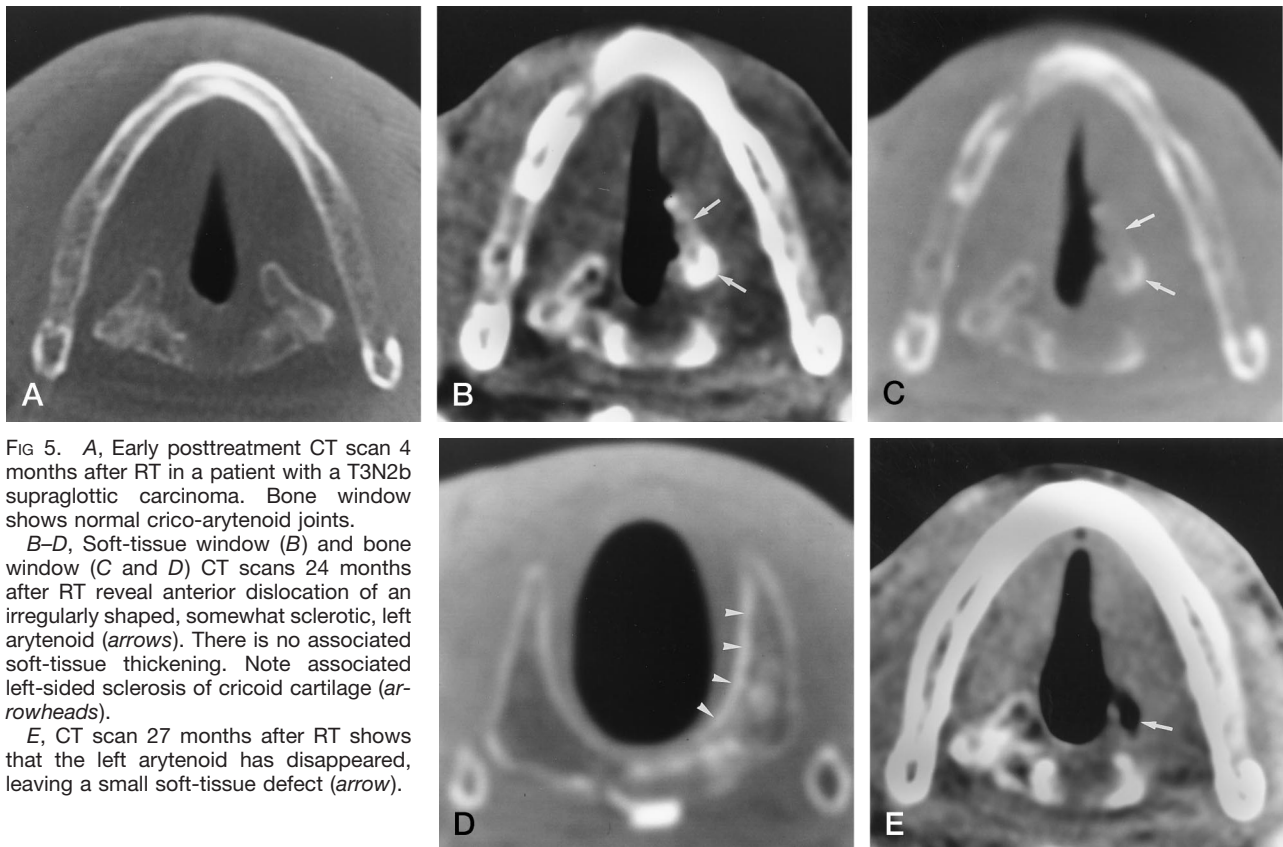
A, Early posttreatment CT scan 4 months after RT in a patient with a T3N2b supraglottic carcinoma. Bone window shows normal crico-arytenoid joints.
